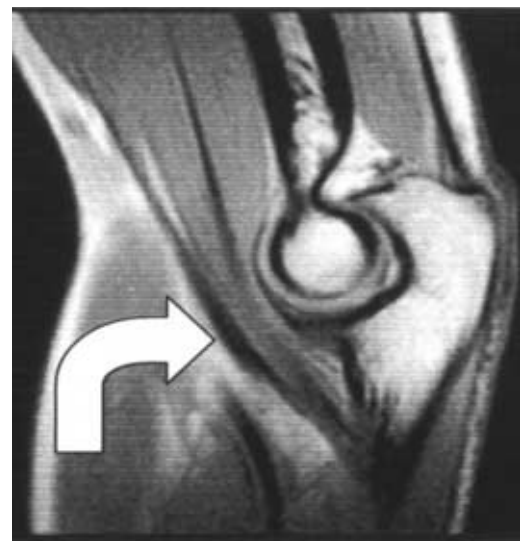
Normal Biceps MRI: Tendon indicated as it passes anterior to elbow joint.
